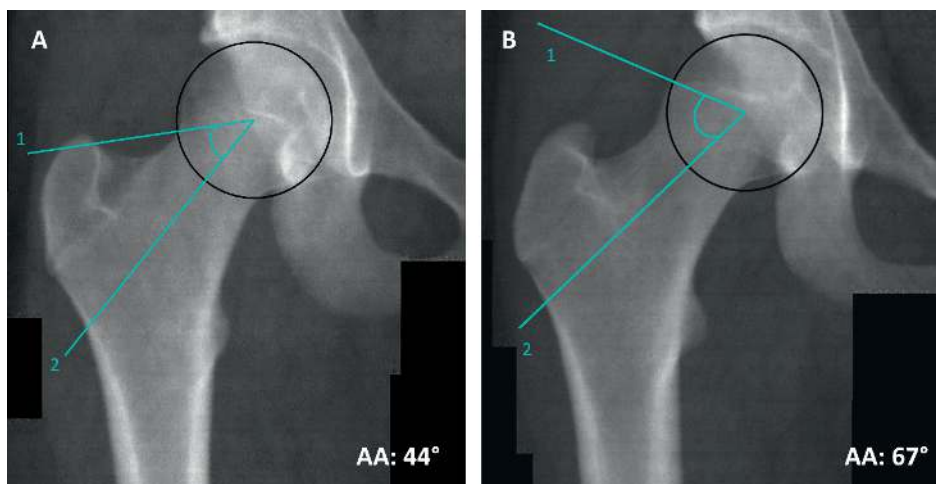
Measurement of the alpha angle (AA) on a dual-energy x-ray absorptiometry (DXA) image of the right hip. The alpha angle is formed between the intersection of two lines. The first line connects the center of the best-fitting circle around the femoral head to the point where the femoral head first departs from the margin of the best-fitting circle, and the second line connects the center of the best-fitting circle to the center of the femoral neck. (A). The alpha angle of 44° is shown, indicating a spherical femoral head. (B). The alpha angle of 67° is shown, indicating a primary cam morphology.
